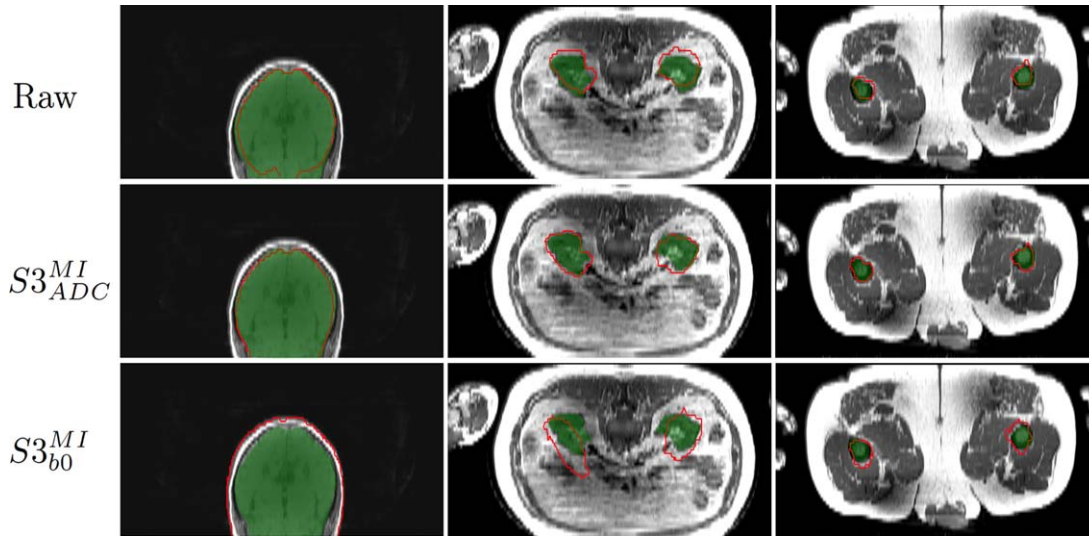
Organs segmented from DWI stations (red) aligned with organs segmented from the T_1 whole-body image (green) before and after the registration process. The same slice from each 3D volume covering brain (left), kidneys (middle), and femur bones (right) is shown in the axial plane. The influence of the used image (ADC or b_0) is presented for the same method (S3). Strategies driven by ADC image stations showed higher T_1 to DWI registration accuracy. Unnatural image deformations were present in methods using b_0 images.
